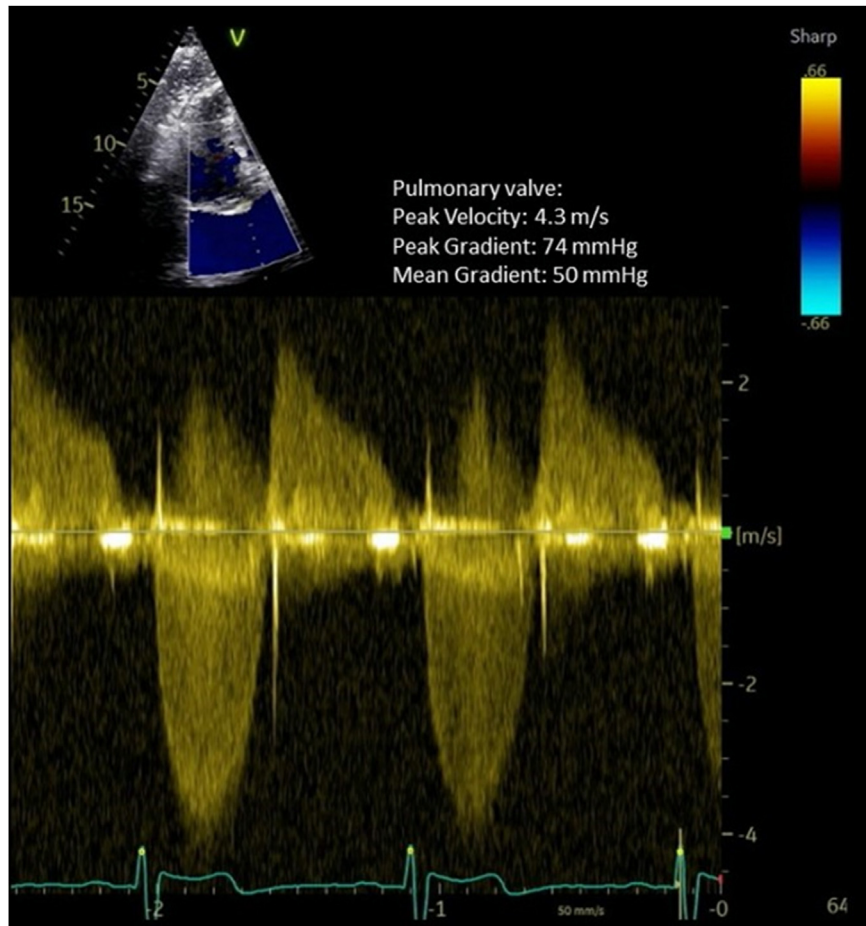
Two-dimensional TTE continuous-wave Doppler tracing, anterior tilt apical 5-chamber view, demonstrates severe PS and moderate PR.
